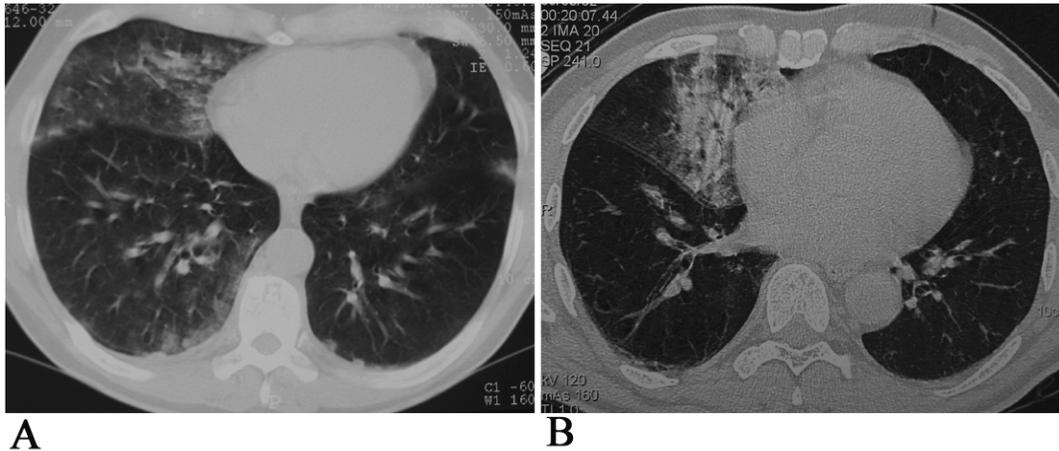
Chest CT scan performed immediately after the accident in case 2 (A) and in case 3a (B), showing patchy ground-glass opacifications predominantly within the right middle lobe.
